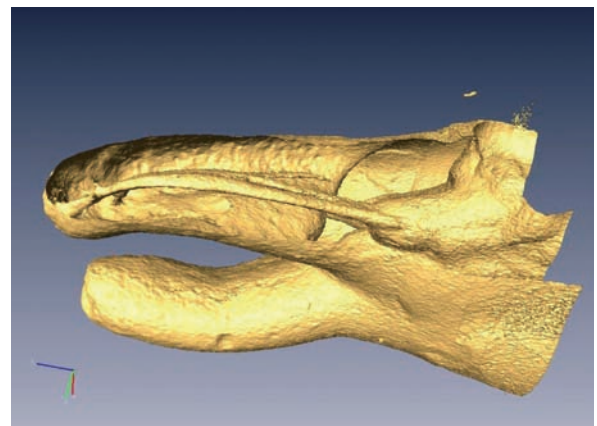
Bucco-lingual section of the same root of Fig. 6, this cut evidences the common radiographic projection, in which it is possible to observe the curvature of the mesio-buccal root canal space, but where the complexity of this extremely difficult root canal space is missed.
